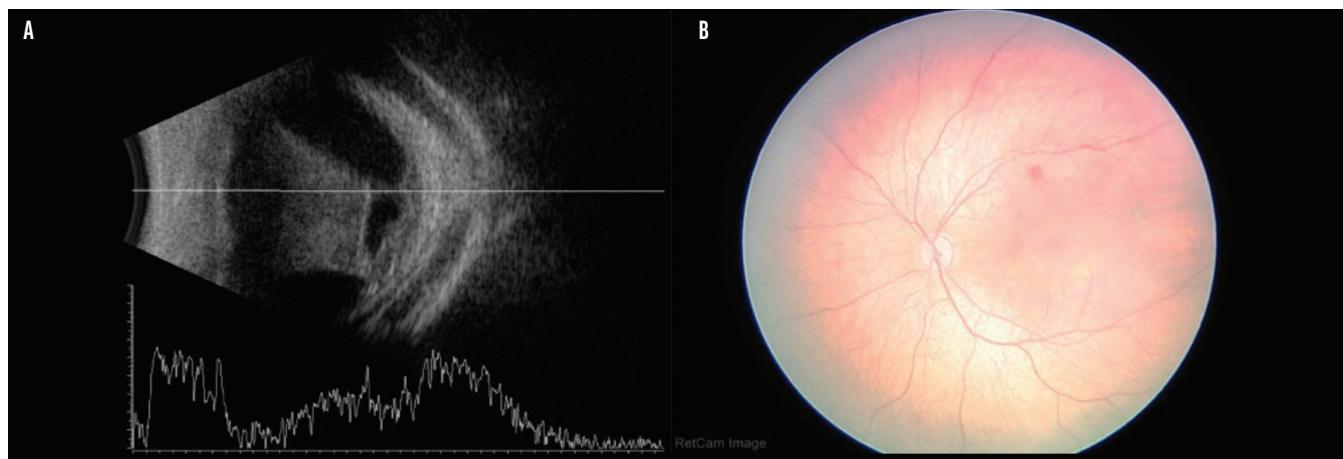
B-scan ultrasound of the right eye shows VH in association with Terson syndrome (A). Fundus photography of the left eye shows intraretinal hemorrhage (B).
